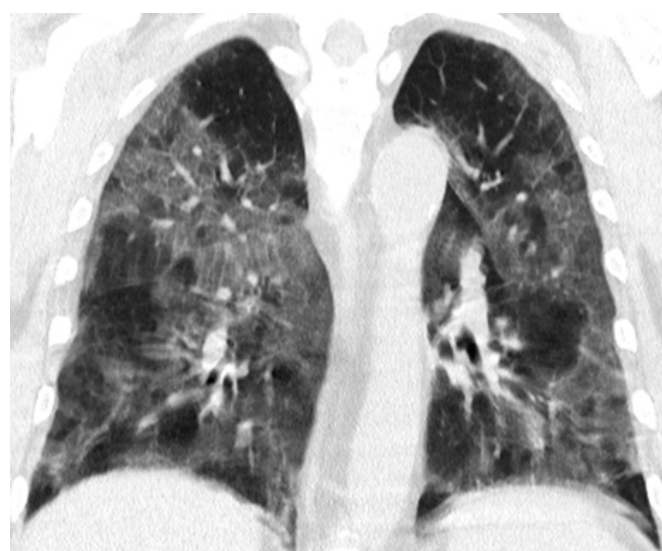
Chest CT scan- Coronal lung window- Extensive confluent bilateral ground glass opacities which associates interlobular septal thickening, related to COVID-19 pneumonia.
